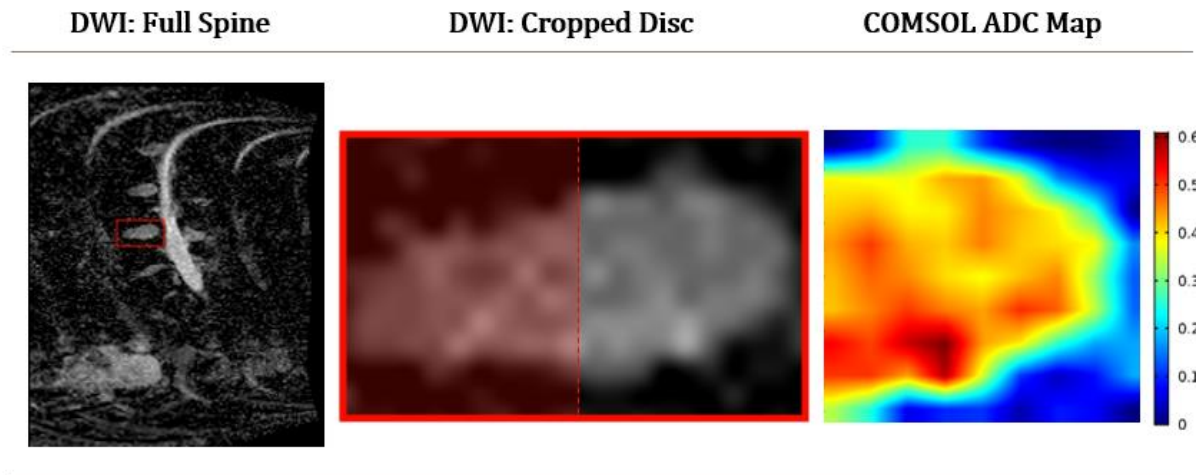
Image processing stages for Patient #1: the diffusion weighted image (DWI) of the whole spine with contrast enhancement (left), the cropped disc segment selected for modeling (middle), and the final cropped disc image as used in COMSOL. Note that the final image is cropped in half, allowing it to be wrapped 360° around the axis of symmetry assigned to the left y-axis, yielding the cylindrical shape that approximates that of a spinal disc (Figure 2.4).
